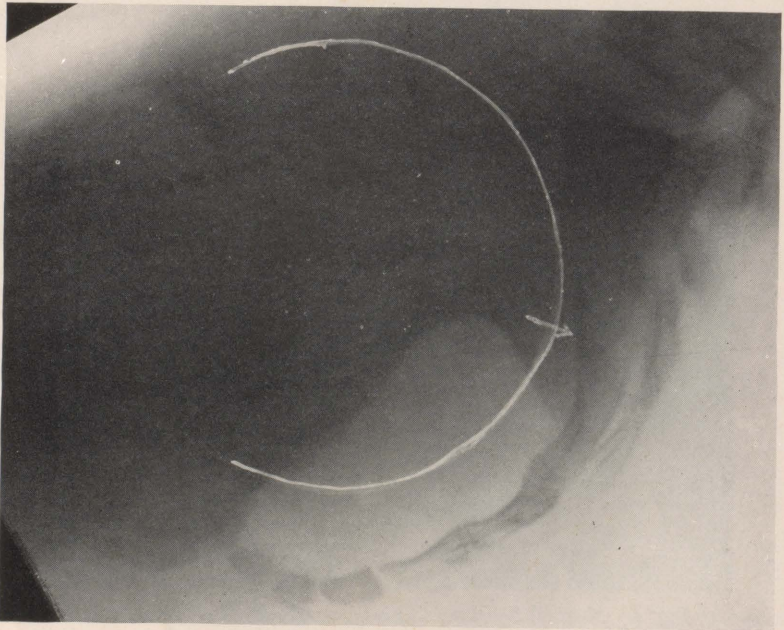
A, B, and C. X-ray studies of the sacrum. The inner surface of this bone is quite flat as compared with the normal. This is more obvious upon digital examination through the rectum. The arrows indicate the flat area. The straight coccyx and anal deformity may or may not accompany this type of sacrum. The latter defects may be present singly as described.
